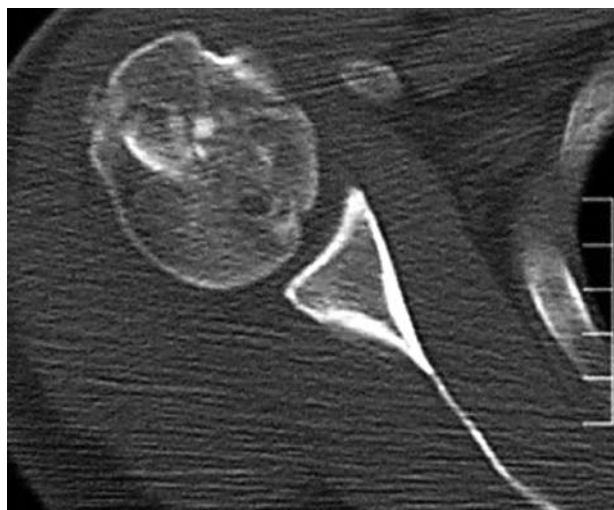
Postoperative axial CT image of the shoulder at 2 weeks.
